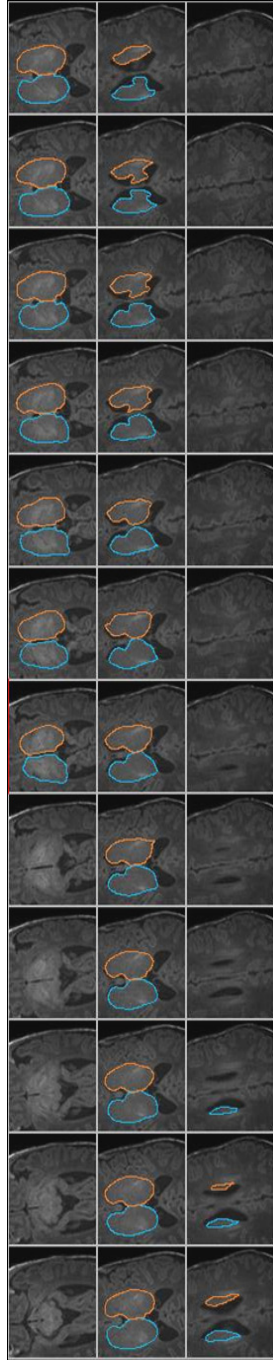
Example of manual segmentation of the basal ganglia and thalami on consecutive slices of a T₁-weighted MRI examination of a very preterm infant scanned around term equivalent age.
